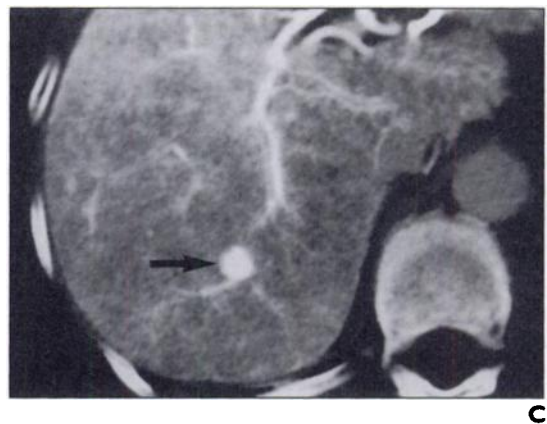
Types of findings on CT during hepatic arteriography.
